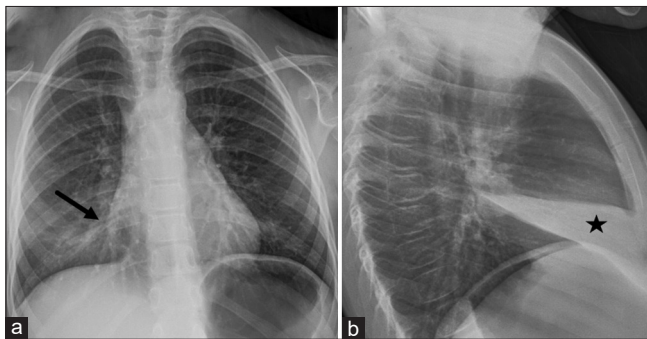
A 4-year-old female with chlamydia pneumonia. (a) Frontal chest radiograph shows lobar consolidation in the right middle lobe. Note how the right heart border is obscured on the frontal view (black arrow). (b) This corresponds to the consolidation in the right middle lobe on the lateral view (black star)
